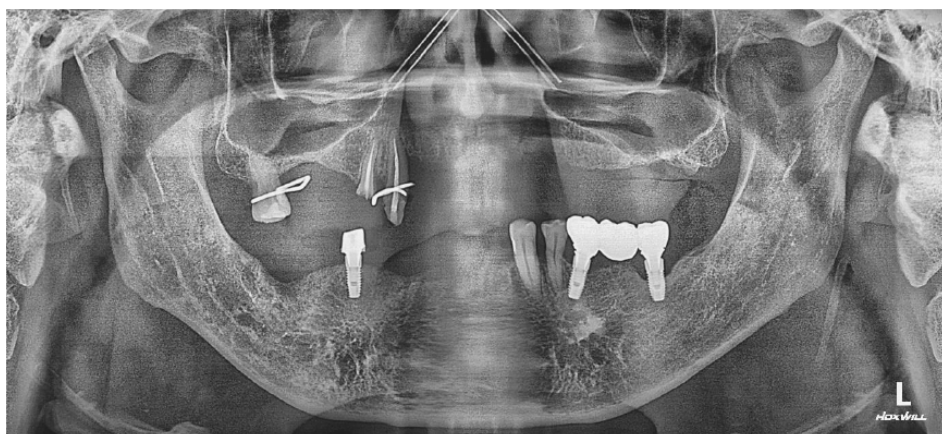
Panoramic radiograph after extraction of #44, 43, 31, 32 teeth.
